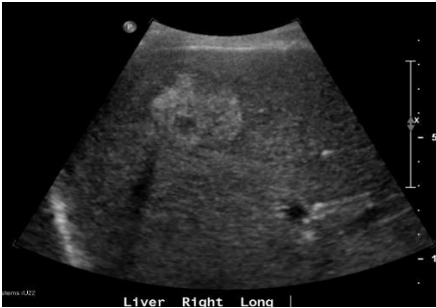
Ultrasound hepatobiliary system showing the 4.7 x 3.8 x 3.9 cm hyperechoic mass.
